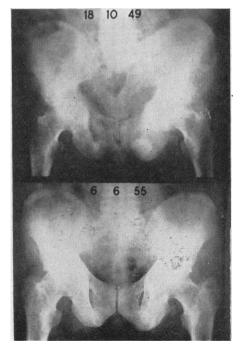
X-rays of the pelvis showing control of secondary deposits in a patient receiving æstrogen therapy for over six years
